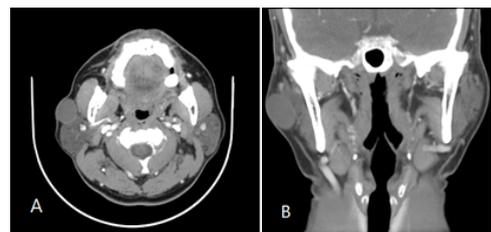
CT Neck W/IV contrast, a, axial view. B, coronal view
